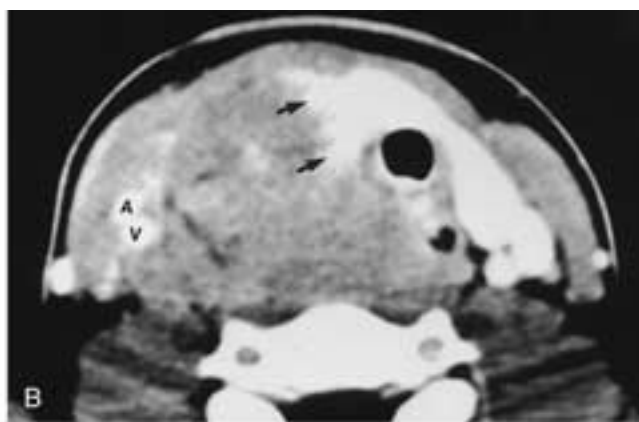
NHL involving the thyroid gland in a 10-year-old boy with airway obstruction. A, Lateral plain film shows that the retropharyngeal soft tissues are prominent and the airway is narrowed. B, Axial contrast-enhanced CT shows a large right nonenhancing neck mass involving the right lobe of the thyroid (*arrows*) and extending behind the trachea and esophagus. The common carotid artery (*A*) and internal jugular vein (*V*) are pushed laterally.
